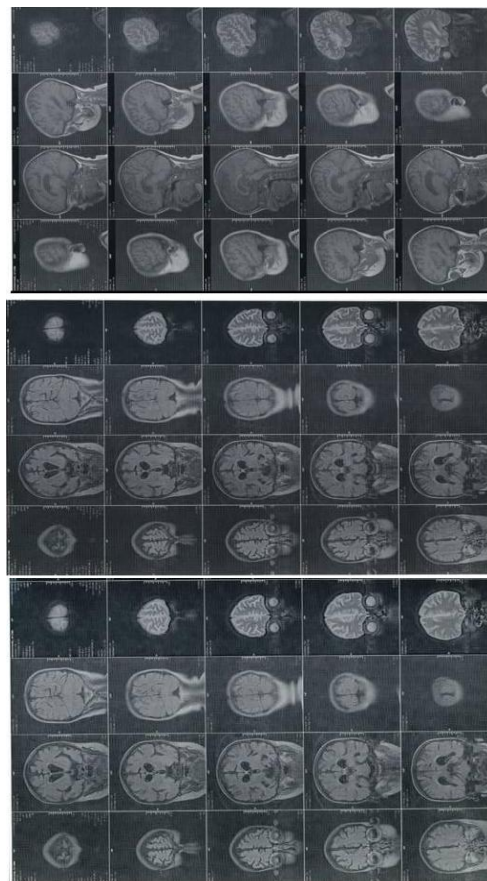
Magnetic resonance imaging. (MRI) of the brain MR imaging of the brain was performed on a 1.5 Tesla superconducting magnet using Axial T2 & FLAIR, Sagittal T1&T2 & Coronal T2 weighted sequences without Gd. The ventricles and sulci are generally dilated (pseudo brain atrophy due to steroid therapy)
